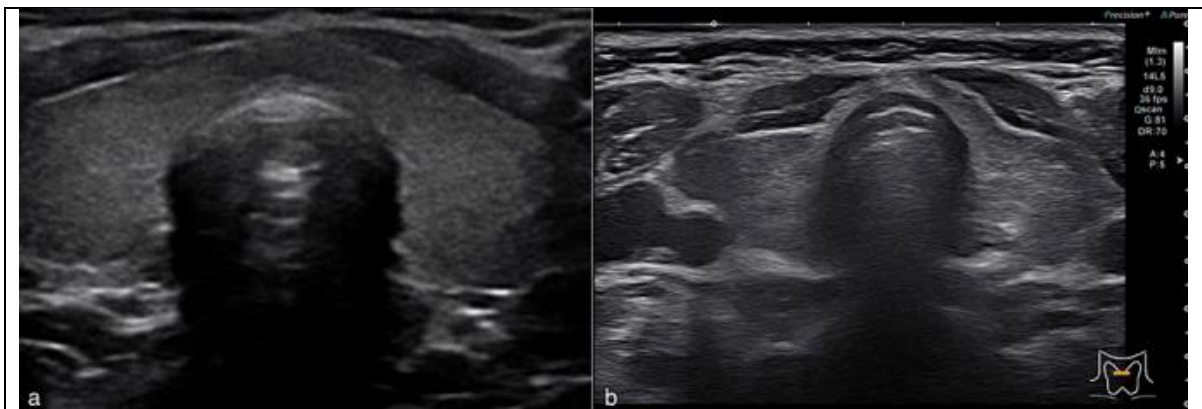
a) Normal thyroid gland ultrasound showing homogeneity b) A thyroid gland ultrasound of the patient revealing a small amount of heterogeneity.
